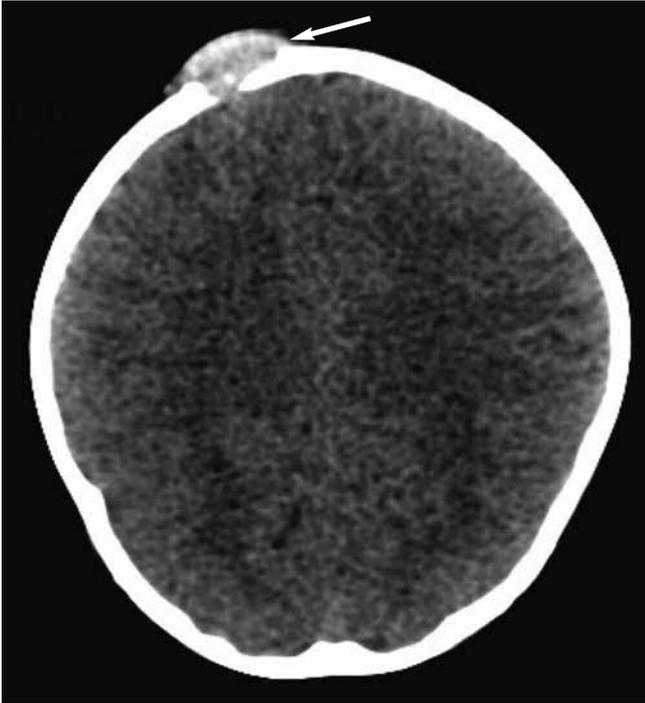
CT scan of the skull showing lytic lesion on the frontal bone.
